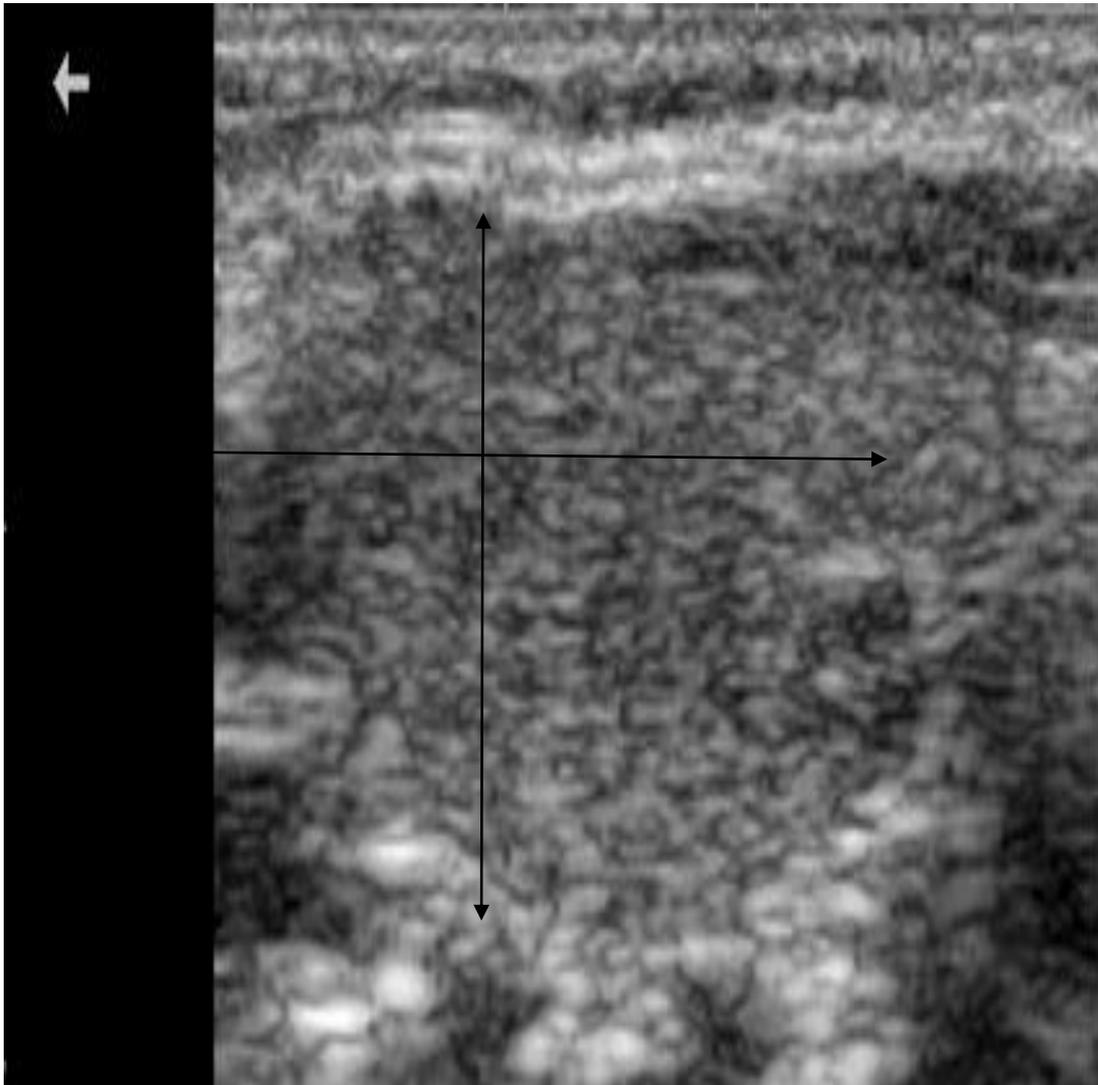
Longitudinal ultrasound scan of the thyroid, showing measurement of the longitudinal (LS) and anteroposterior diameters of the thyroid lobe.
